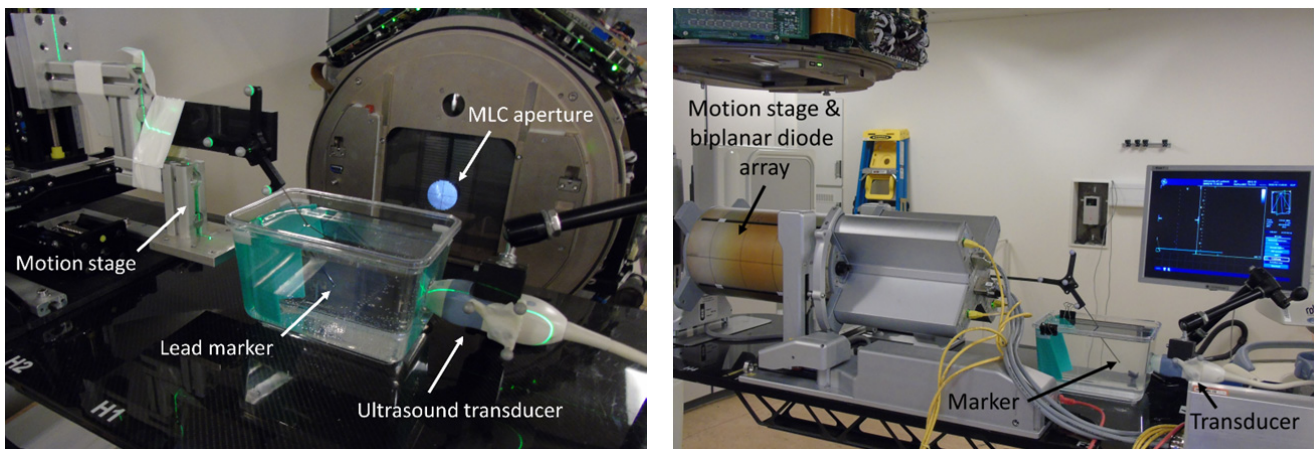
(a) Setup for geometric accuracy assessment of online ultrasound-guided MLC-tracking. A lead sphere in a water bath was moved by a motion stage, detected with 4D ultrasound and its position sent to the MLC tracking software which calculated and updated the MLC
